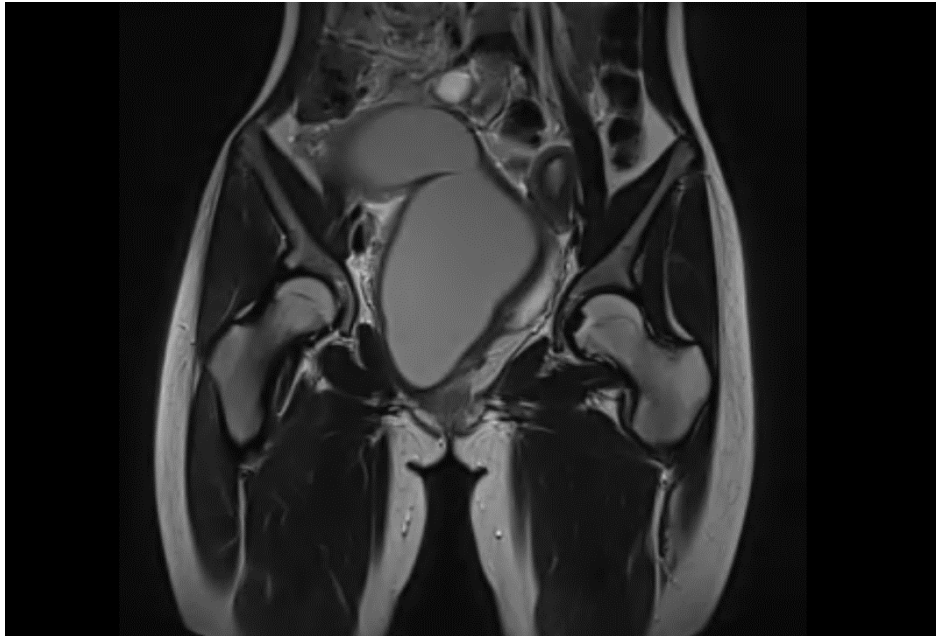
Coronal T2-weighted pelvic MRI showing uterus didelphys with marked distension of the right hemivagina and right hemiuterus due to obstruction, resulting in hematometra and hematocolpos (hyperintense fluid signal). The left hemivagina and left hemiuterus appear non-distended.
